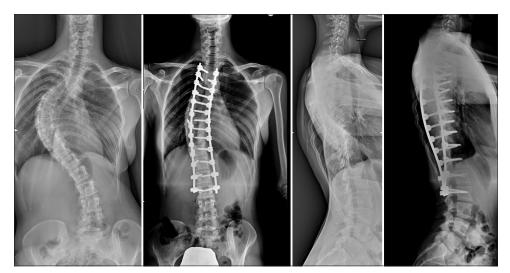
Female, 18 years old present with severe adolescent idiopathic scoliosis with pre-operative Cobb angle of main curve of 94°, underwent one-stage PSF with multiple periapical asymmetrical Ponte osteotomies. Postoperative Cobb angle was 38° with a coronal correction rate of 59.6%. PSF: Posterior-only spinal fusion
